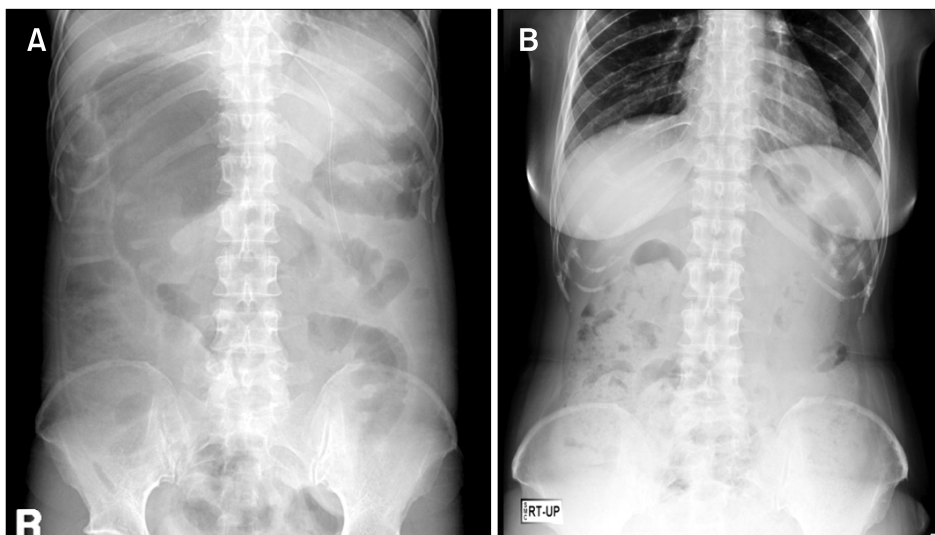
Abdomen supine X-ray. (A) Severely dilated proximal transverse colon. (B) Improvement of dilated colon after medical treatment.
